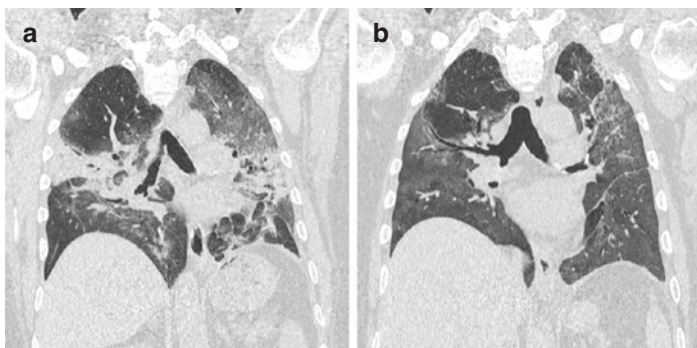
A 67-year-old man with acute respiratory insufficiency. (a) Coronal multiplanar reformatted CT. Bilateral consolidations in the middle portion of both lungs, associated with peripheral GGOs. (b) After 1 month reduction of consolidations with residual diffuse GG
